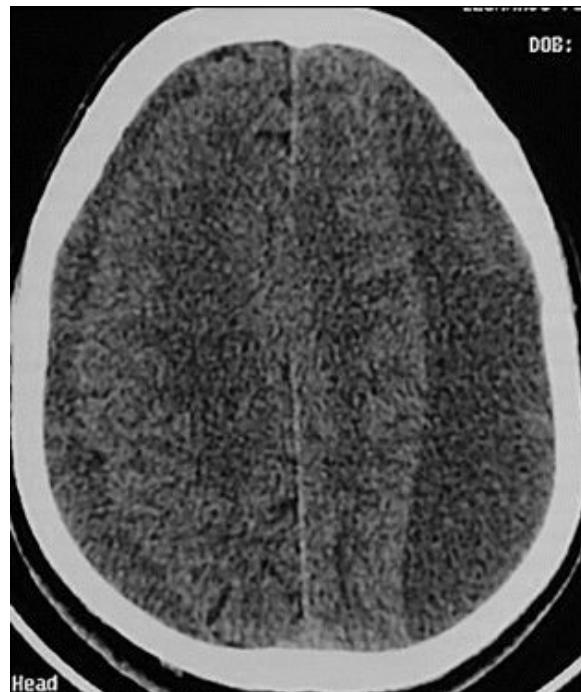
Non-contrast-enhanced cranial CT demonstrating bilateral frontoparietal hypodense lesion, compatible with chronic subdural hematoma.
